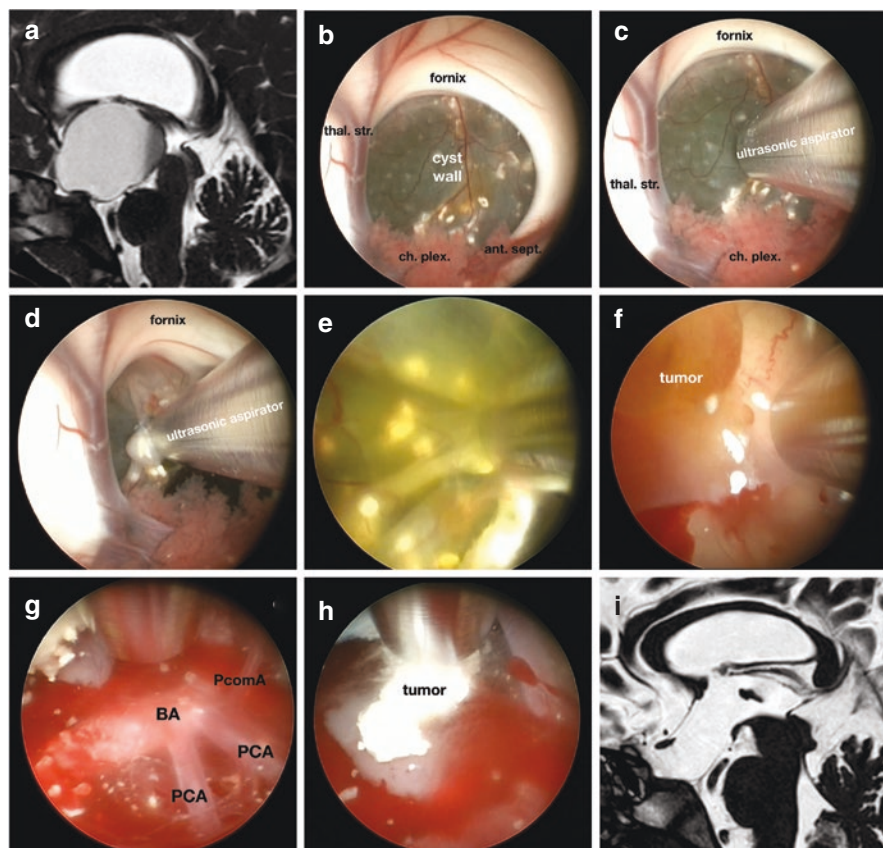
Transforaminal endoscopic pre-coronal approach: Five-year-old boy with headache and papilledema. MRI shows a voluminous lesion with large intrasuprasellar cystic component, involving the third ventricle and causing foraminal obstruction with obstructive hydrocephalus (a). The lesion is approached via left pre-coronal pure endoscopic approach. Within the frontal horn of the left lateral ventricle the foramen of Monro, the left thalamostriate and anterior septal veins, the choroid plexus, and the fornix are identified (b). The third ventricle is completely occupied by a cystic lesion with calcific walls. With the help of endoscopic ultrasonic aspirator (c, d), the cystic wall is perforated and motor oil-like fluid is observed to leak out (e). Total excision of the tumor cyst and solid components (f, h) is performed until the posterior arterial circulation is visualized (g). Postoperative MRI shows complete excision of the lesion, which was found to be an adamantinomatous craniopharyngioma (i)
